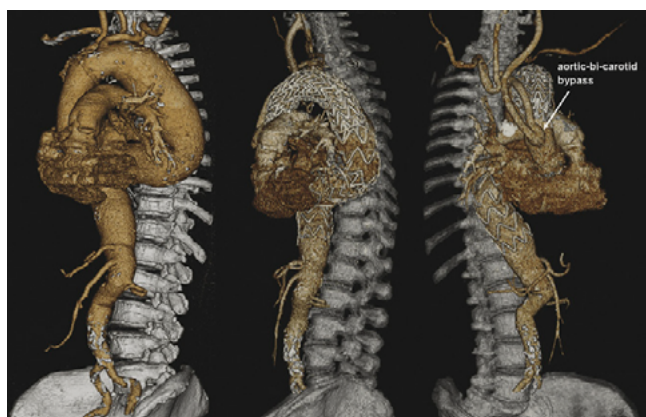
Preoperative 3D-MRI with aortic arch and thoracoabdominal aneurysm (Crawford type I) involving the supra-aortic great arteries (left); postoperative 3D-MRI after endovascular stent-graft implantation with three stent-grafts covering the entire aortic arch to the celiac axis (middle), and aortic-bi-carotid bypass using woven prosthesis (right).
